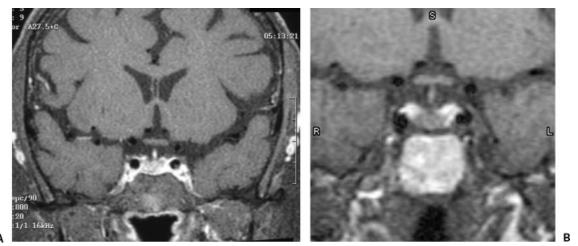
(Case 4) (A) T1-weighted coronal 1.5T MRI and (B) 3T MRI with contrast show enhancement of the intrasellar contents with no clear radiographic definition of the tumor. IPSS indicated a strong left-sided ACTH gradient with a high central-to-peripheral ratio. A left-sided ACTH-secreting adenoma was confirmed at surgery. IPSS, inferior petrosal sinus sampling; ACTH, adrenocorticotropic hormone.
